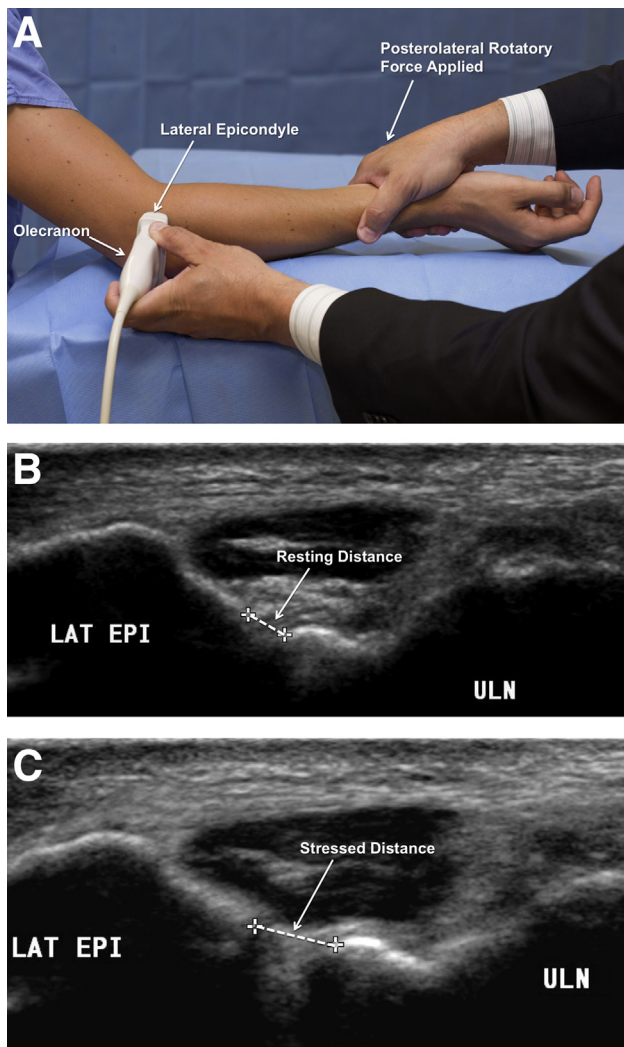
Ultrasound can be used to assess the elbow for posterolateral rotatory instability by measuring the extent to which the posterolateral ulnohumeral joint opens when stressed. With one hand, the ultrasonographer places the probe in the anatomic axial plane spanning from the patient's olecranon to the lateral epicondyle (A). With the other hand, a posterolateral rotatory stress is applied to the wrist or the forearm. The difference in ulnohumeral widening between the resting (B) and stressed (C) state is noted. (LAT EPI, lateral epicondyle; ULN, ulna.)
